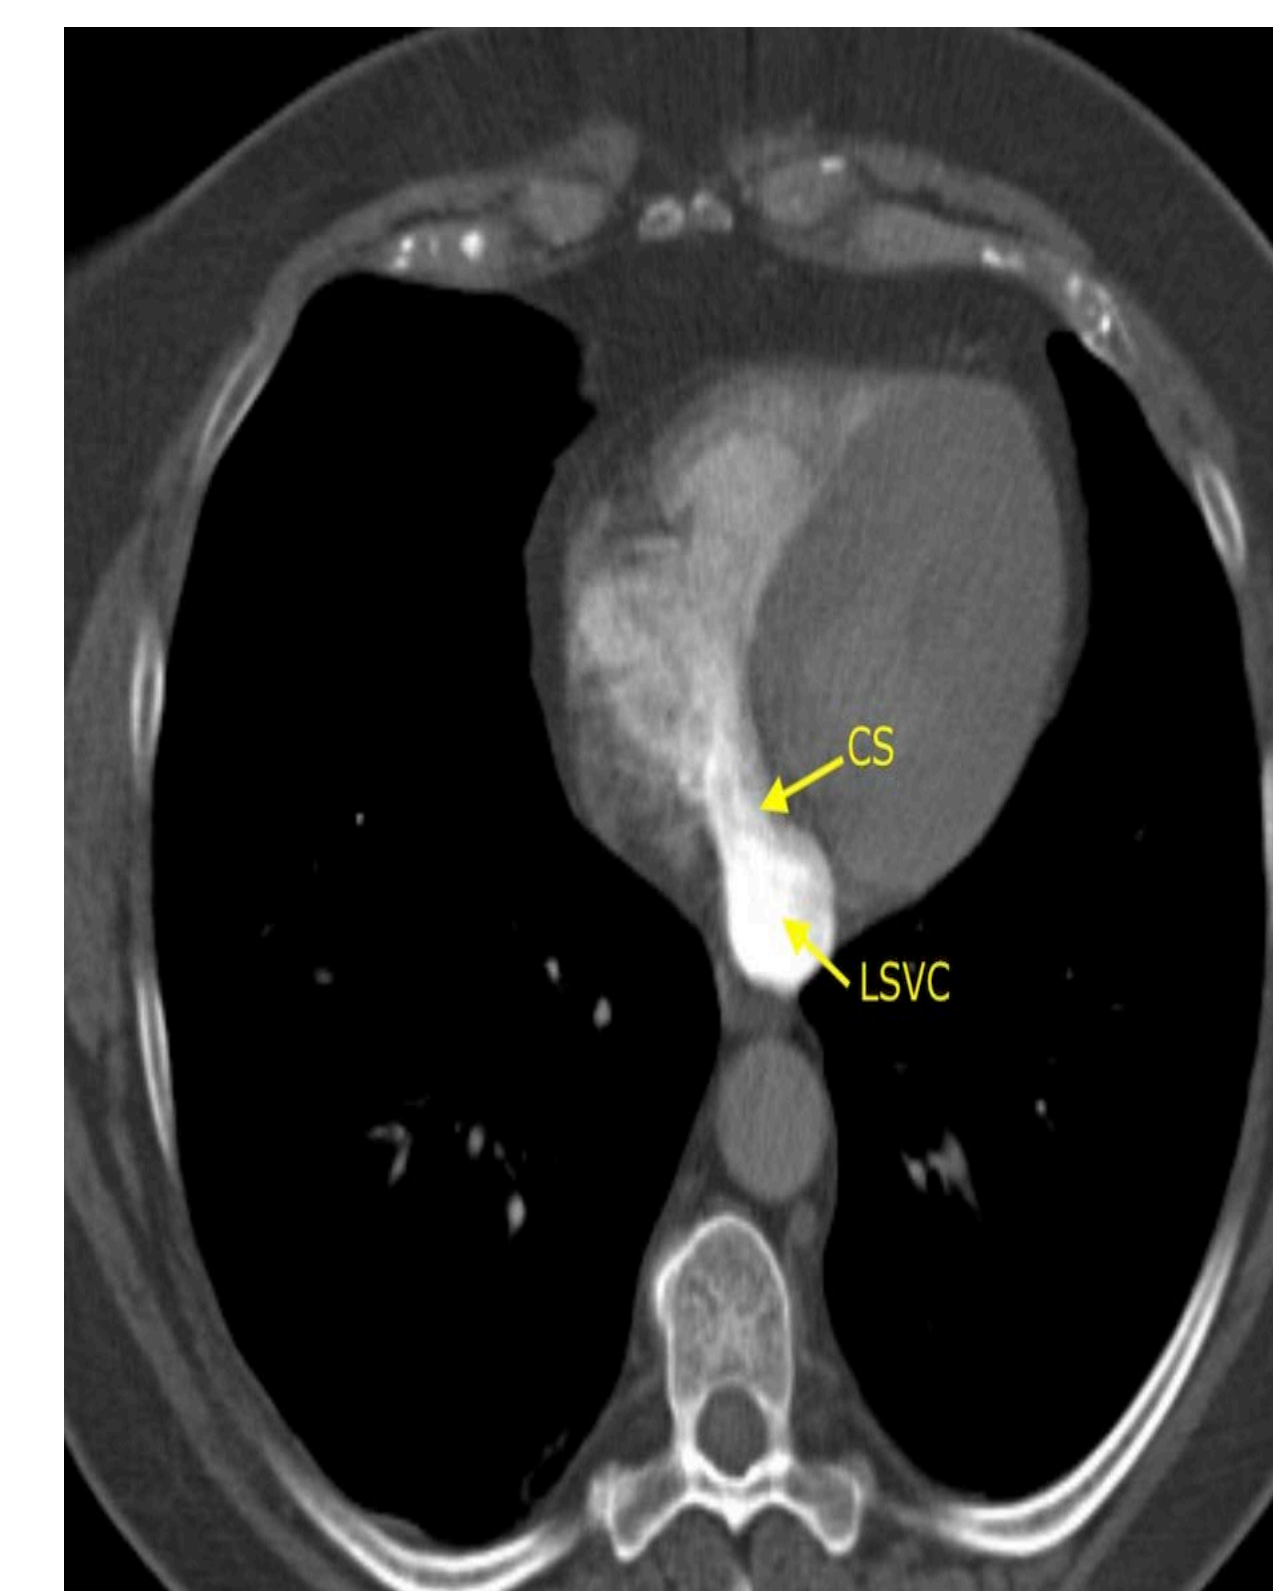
CT Chest showing LSV draining into CS
